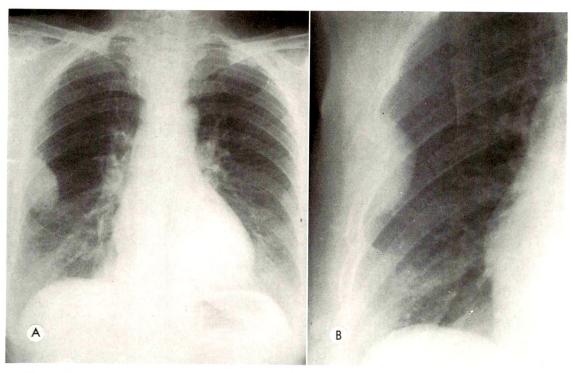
Case III. (A and B) Routine chest roentgenograms show a neoplasm of the right chest wall, with rib destruction and a prominent soft tissue mass, characteristic of myeloma.
